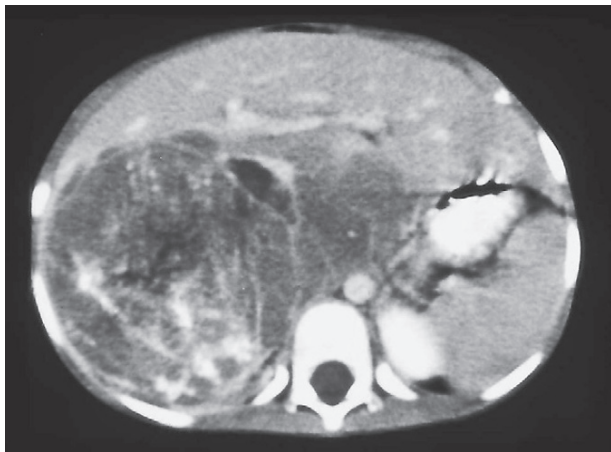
An abdominal CT scan of a child with an abdominal mass. There is an extensive nephroblastoma (Wilms' tumour) of the right kidney.
